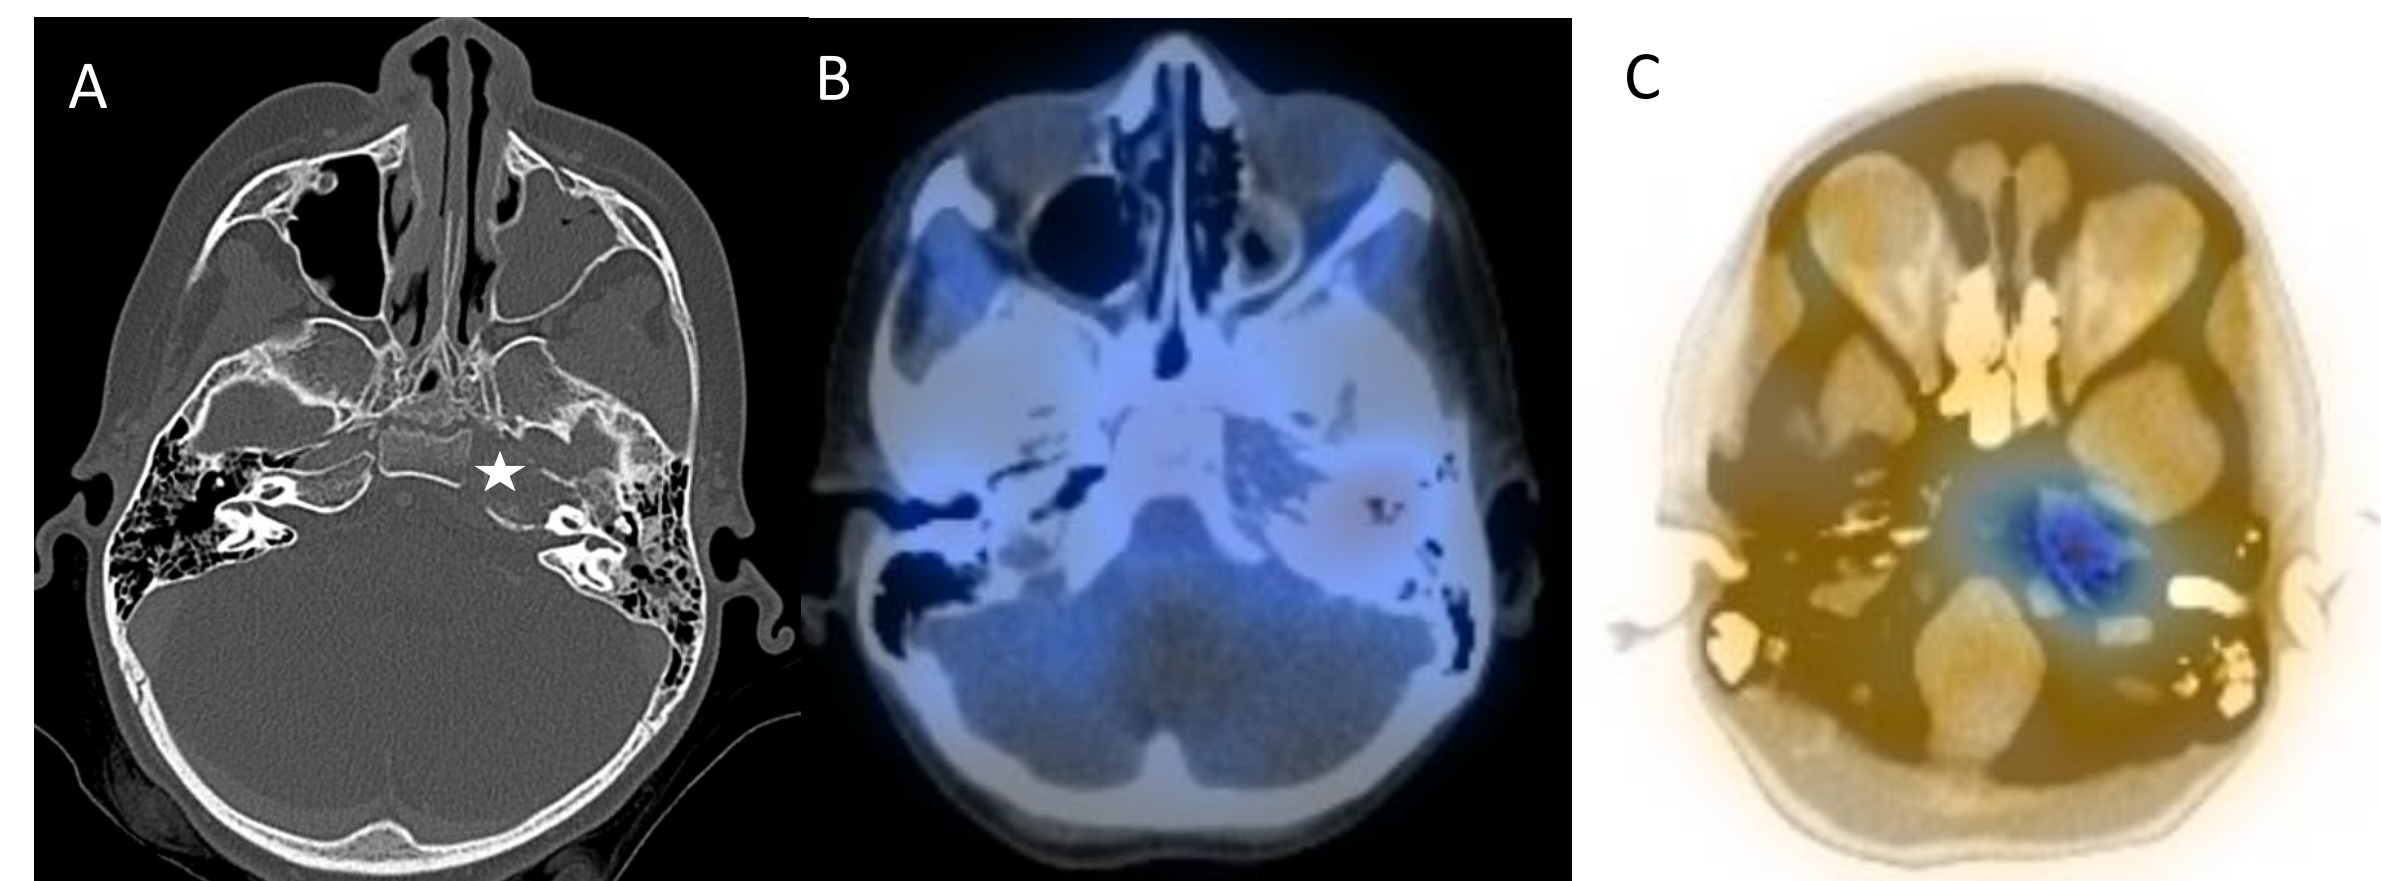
Non-contrast A) CT temporal bone demonstrating expansile lesion with bony destruction at left petrous apex (star); SPECT-CT B) with technetium showed trace uptake C) with gallium demonstrated extensive uptake in the left petrous bone, consistent with extremely active infection.
